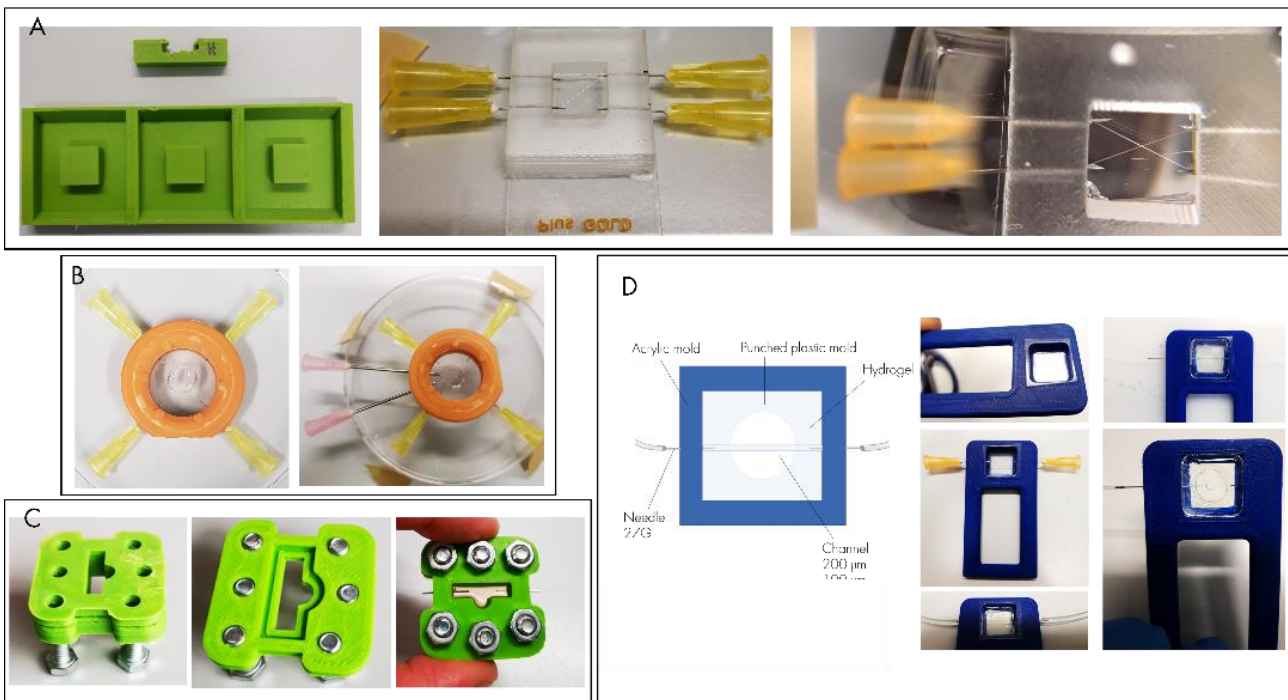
DIFFERENT DESIGN OF THE ACRYLIC HOLDER FOR GELMA/MATRIGEL HYDROGEL. Each of these showed vulnerabilities and inappropriateness for the application of ultrasound due to potential wave distortions or attenuation caused by materials. Another limiting factor was given by the inability to crosslink the hydrogel due to the acrylic mould
